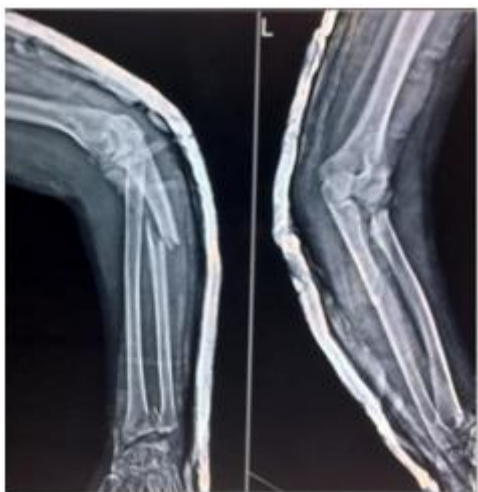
Preoperative anteroposterior and lateral views radiograph of left forearm with elbow and wrist
